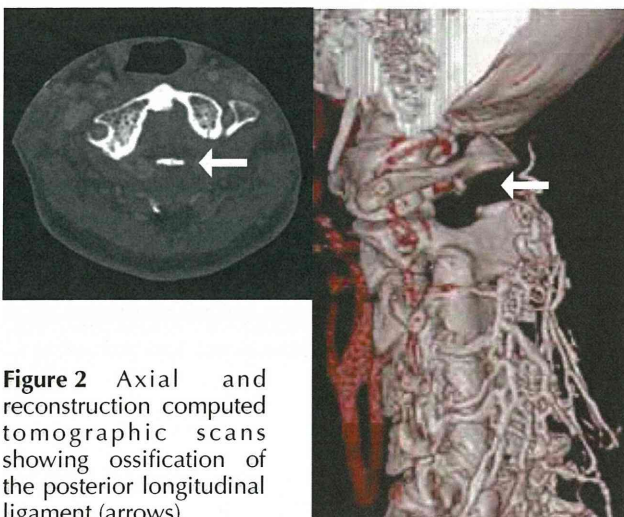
Axial and reconstruction computed tomographic scans showing ossification of the posterior longitudinal ligament (arrows).
